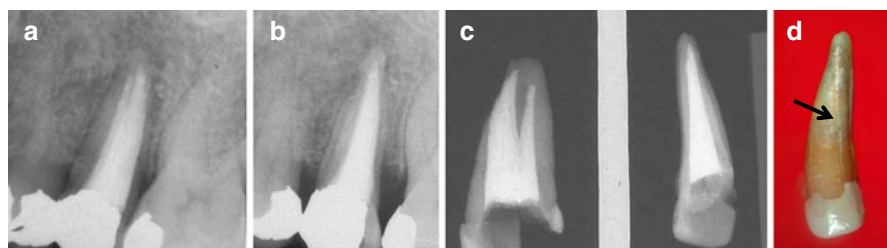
Excessive removal of root dentin is shown in the two periapical radiographs (a, b). A bench periapical radiograph (c) is showing the large amount of dentin removed which was a major contributing etiology for the VRF in this tooth. (d) A black arrow is pointing at the fracture
